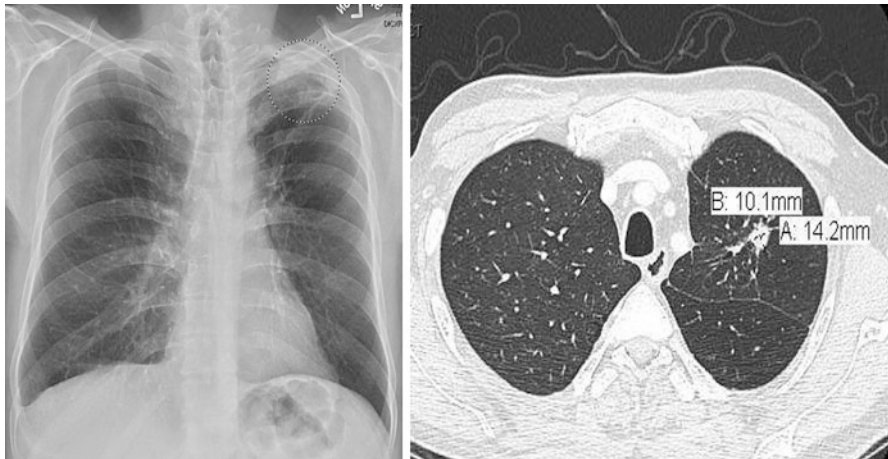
Chest X-ray (*left*) and CT Chest images for case Example 2. There is a lesion involving the upper lobe of the left lung highly suspicious for malignancy. 3 weeks later, Anti Hu antibodies were found to be positive in very high titer
